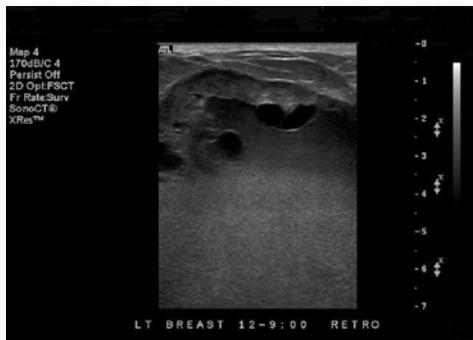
Closer ultrasound of left breast cyst wall showing irregular border.
